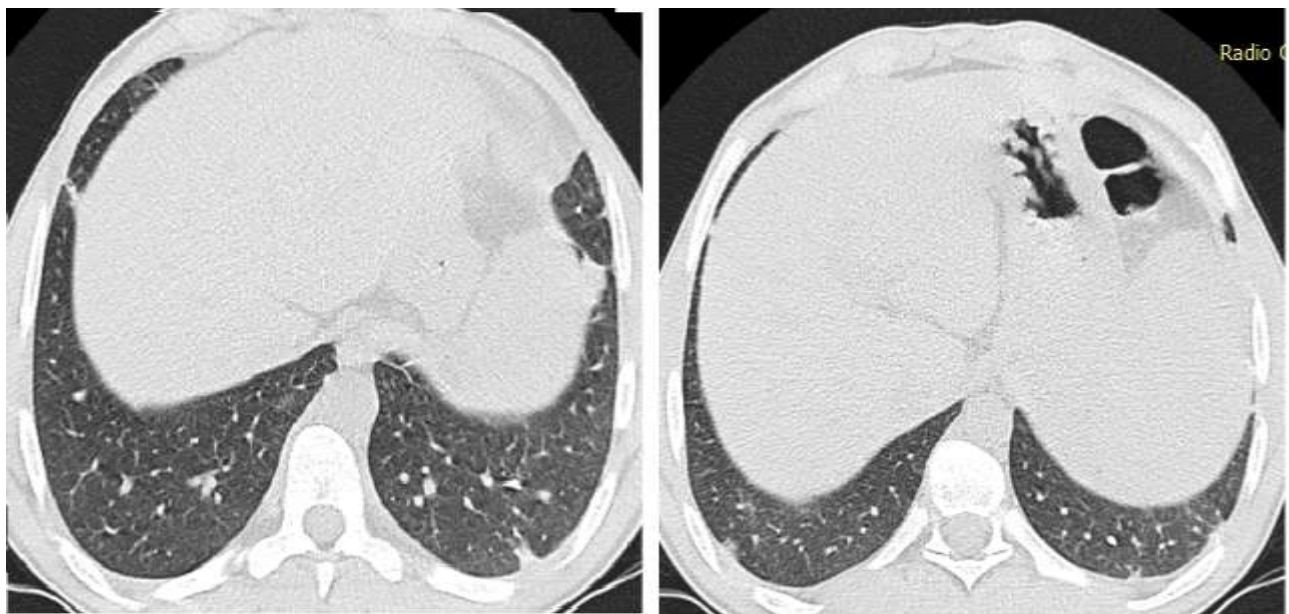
Chest CT scan at D10 objectifying the persistence of spontaneously hyperdense areas.
